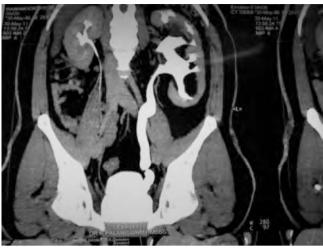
CT image showing ureteric obstruction
